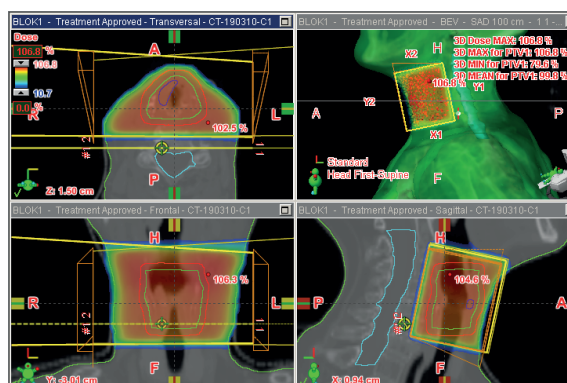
Planning CT-scan of a T1a glottic carcinoma.
